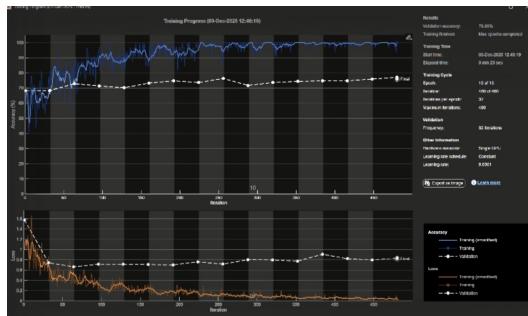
CNN results on ultrasound dataset.
